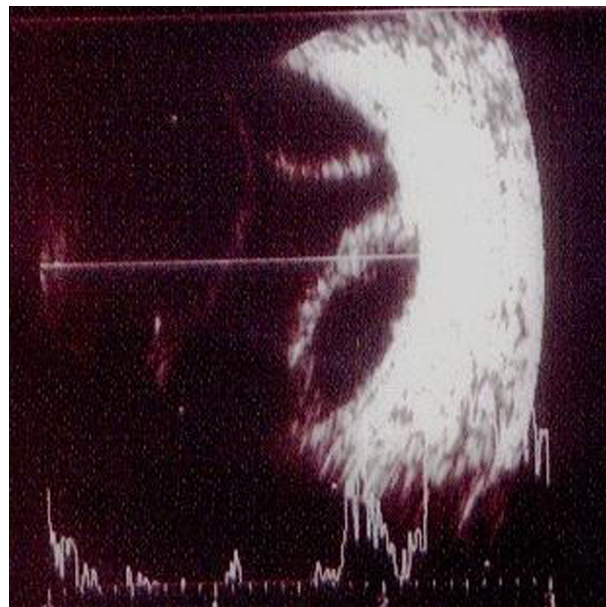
B-scan ultrasound showing serous choroidal detachment.
